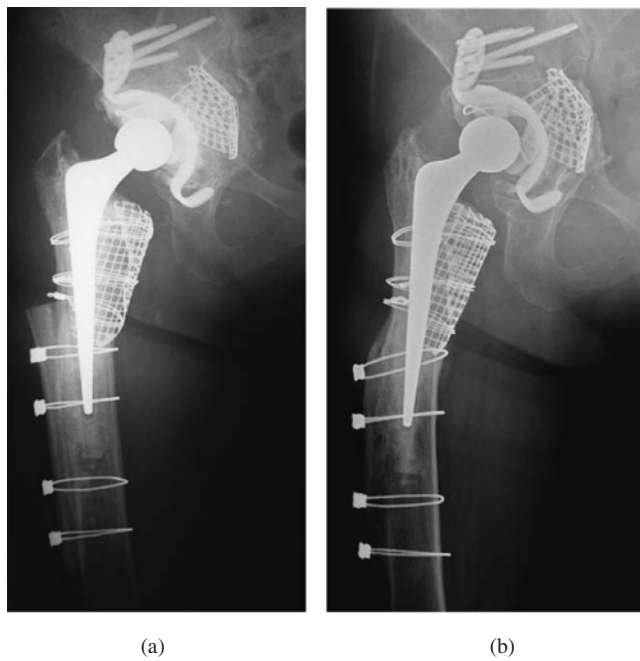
(a) Post-operative radiograph after the second revision THA.
